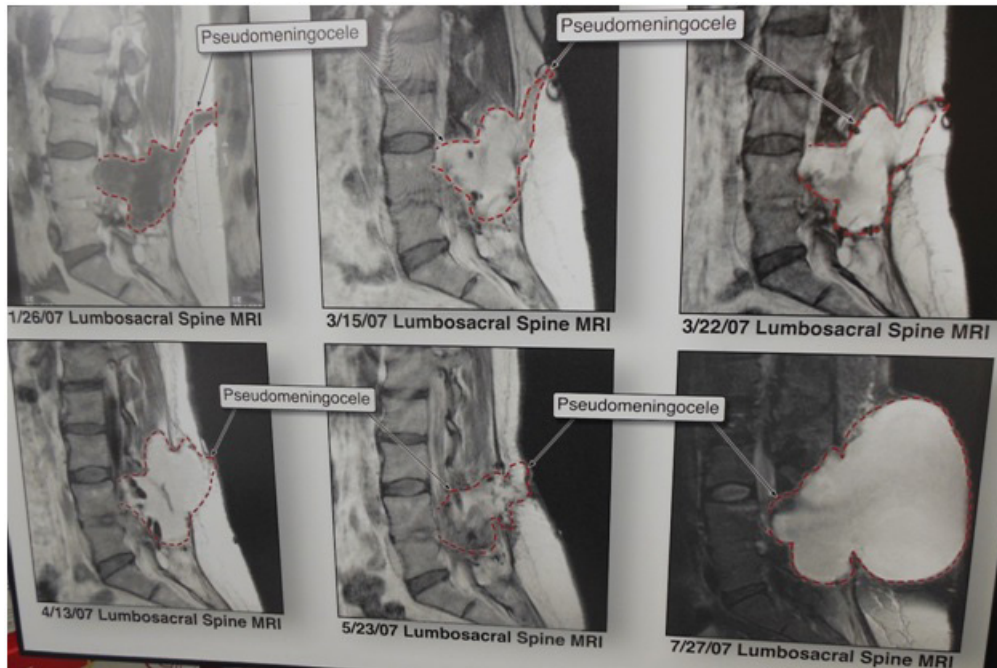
When she returned to the Midwest over Christmas, she began to leak serous fluid from the incision. Sequential MRI studies were performed and by late January of 2007 she had an established pseudomeningocele.
